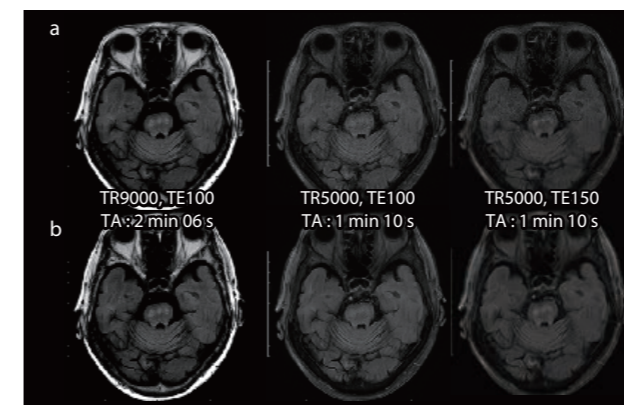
Shorter scan time in FLAIR with AiCE (multiple sclerosis).
